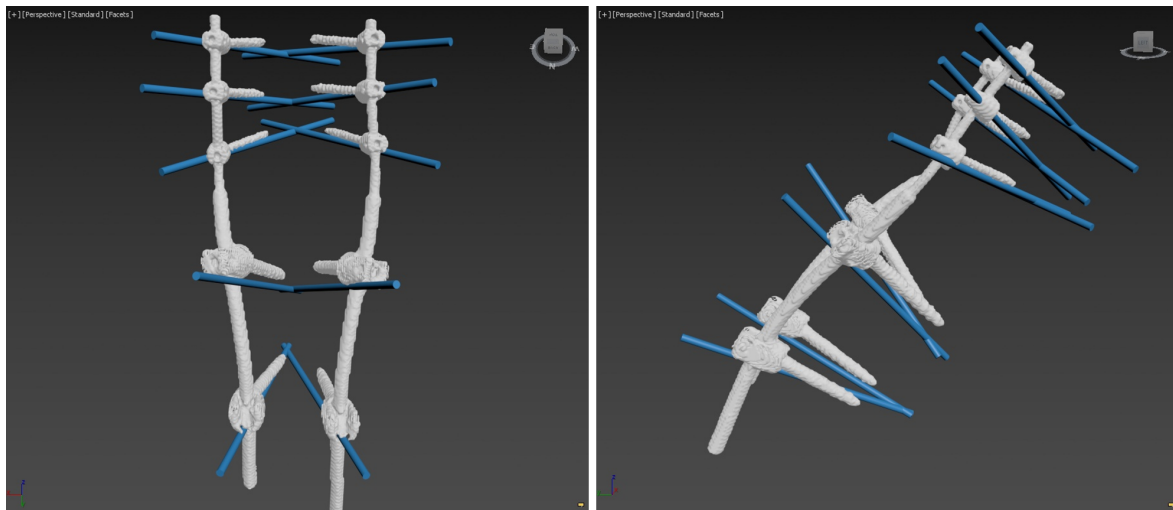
A 3D model of all placed screws, connected with the titanium rods. In blue the planned screw positions are superimposed based on the post-OR CT-scan. This image visualizes the differences between the surgical plan and the actual execution.
